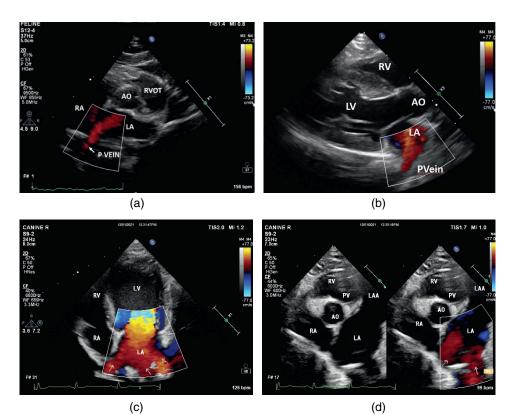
Pulmonary venous flow can be obtained from several left atrial views. The veins are identified by looking for red flow into the left atrial chamber. (a) Right parasternal transverse view of the aorta and left atrium. (b) Right parasternal long axis views. (c) Left parasternal foreshortened apical 4 chamber view. (d) Left parasternal transverse view of the left auricle and atrium.
